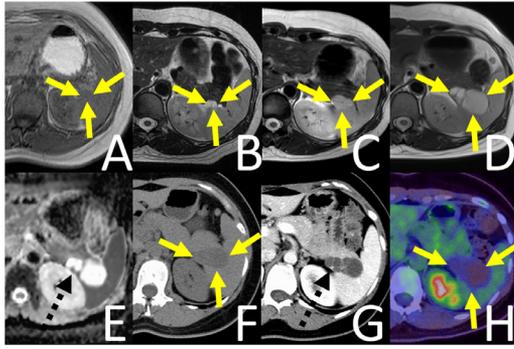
A, B) T1-weighted (A) and T2-weighted (B) images at first MRI. C) T2-weighted image at 4 years after first identification of the lesion. D, E) T2-weighted image (D) and apparent diffusion coefficient map (E) at 5 years after first identification of the lesion. G) Contrast-enhanced CT at 5 years and 3 months after first identification of the lesion. H) FDG-PET/CT at 5 years and 2 months after first identification of the lesion. Arrows indicate the lesion. Dashed arrows indicate mural nodule-like structures.
